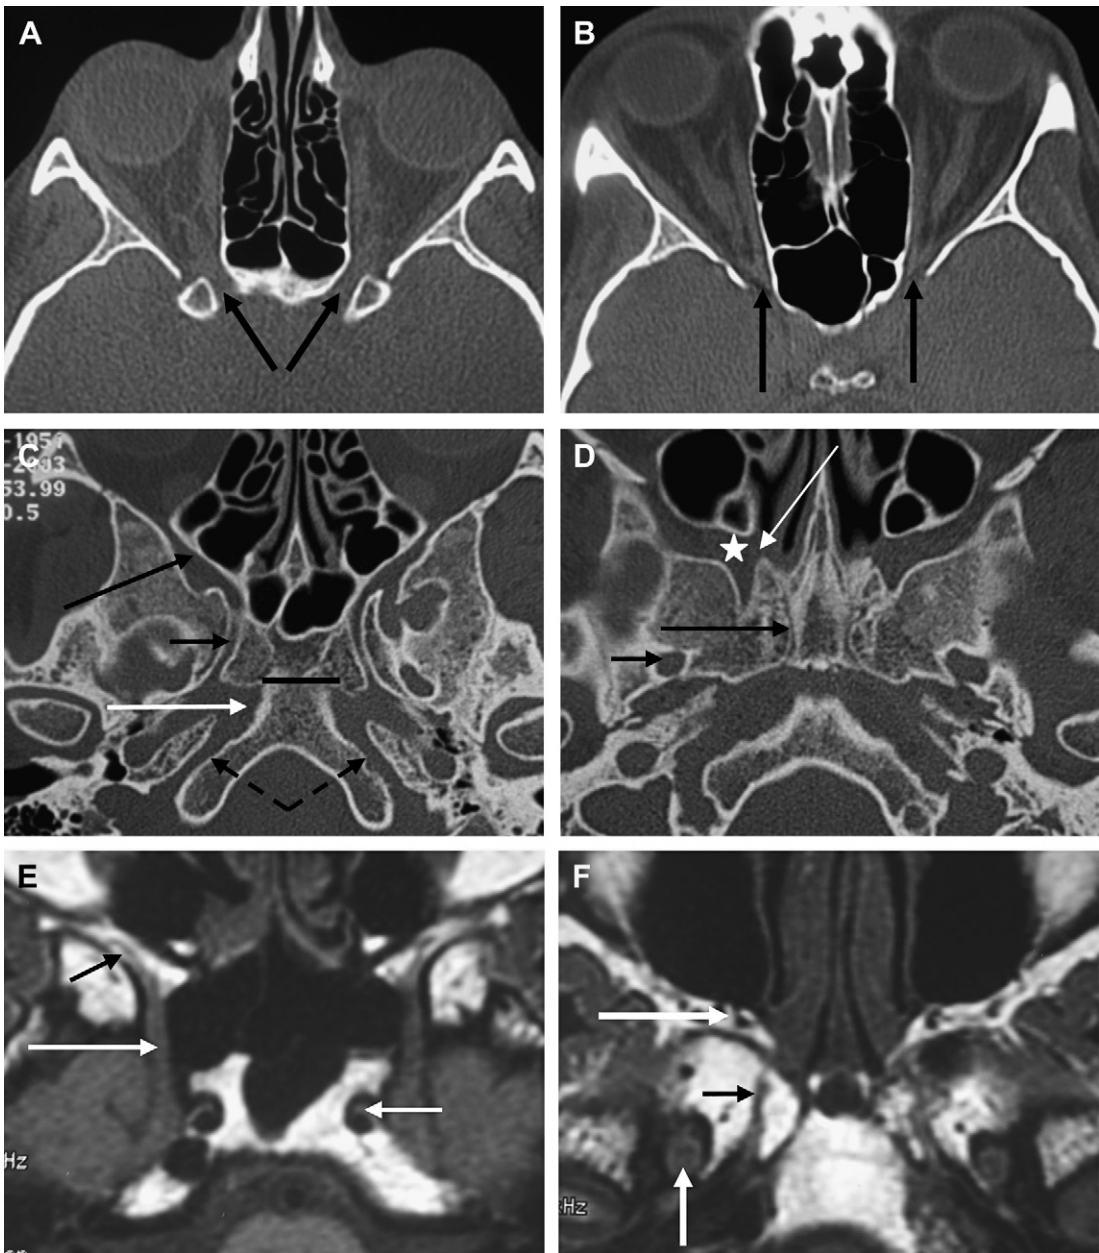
Axial CT sections in a bone algorithm from superior to inferior show (A) the optic canal (*black arrows*); (B) the superior orbital fissure (*black arrows*); (C) the inferior orbital fissure (*long black arrow*), foramen rotundum (*short black arrow*), foramen lacerum (*white arrow*), the petroclival (*dashed black arrows*) and sphenoparietal (*black line*) synchondroses; (D) the high pterygopalatine fossa (*white star*), the sphenopalatine foramen (*long white arrow*); the vidian canal (*long black arrow*) and foramen ovale (*short black arrow*). Axial sensitivity encoding (SENSE) T1W MR images shows (E) V2 within foramen rotundum (*white arrow*), the inferior orbital branch within the inferior orbital fissure (*black arrow*) and (F) V3 within foramen ovale (*white arrow*), the vidian nerve (*short black arrow*) and the sphenopalatine ganglion in the high pterygopalatine fossa (*long black arrow*).
